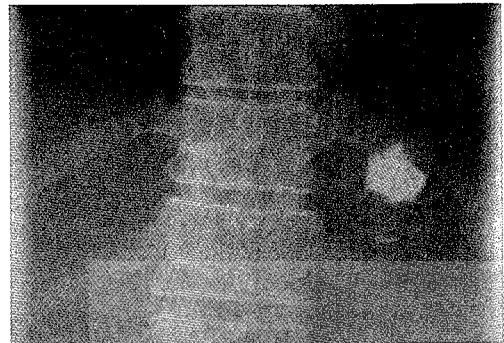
Spine X-ray film show radiopaque shadow of the mixture of Histoacryl and Lipiodol at injected site (arrow).
